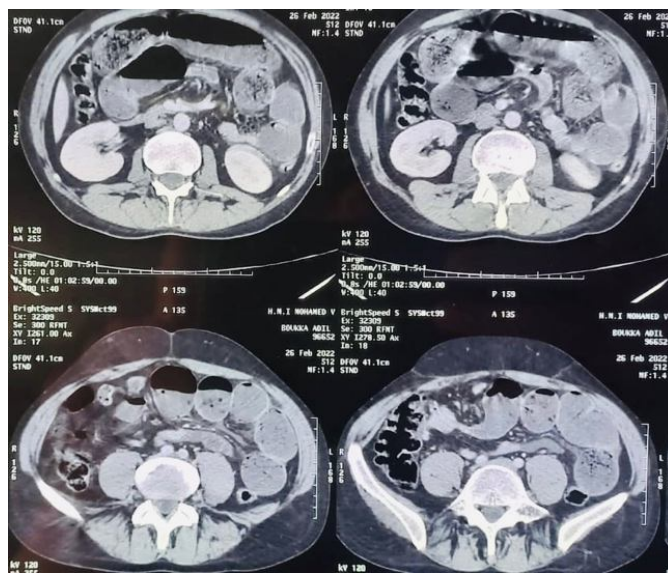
CT-scan imaging showing an obstruction of the small bowel
